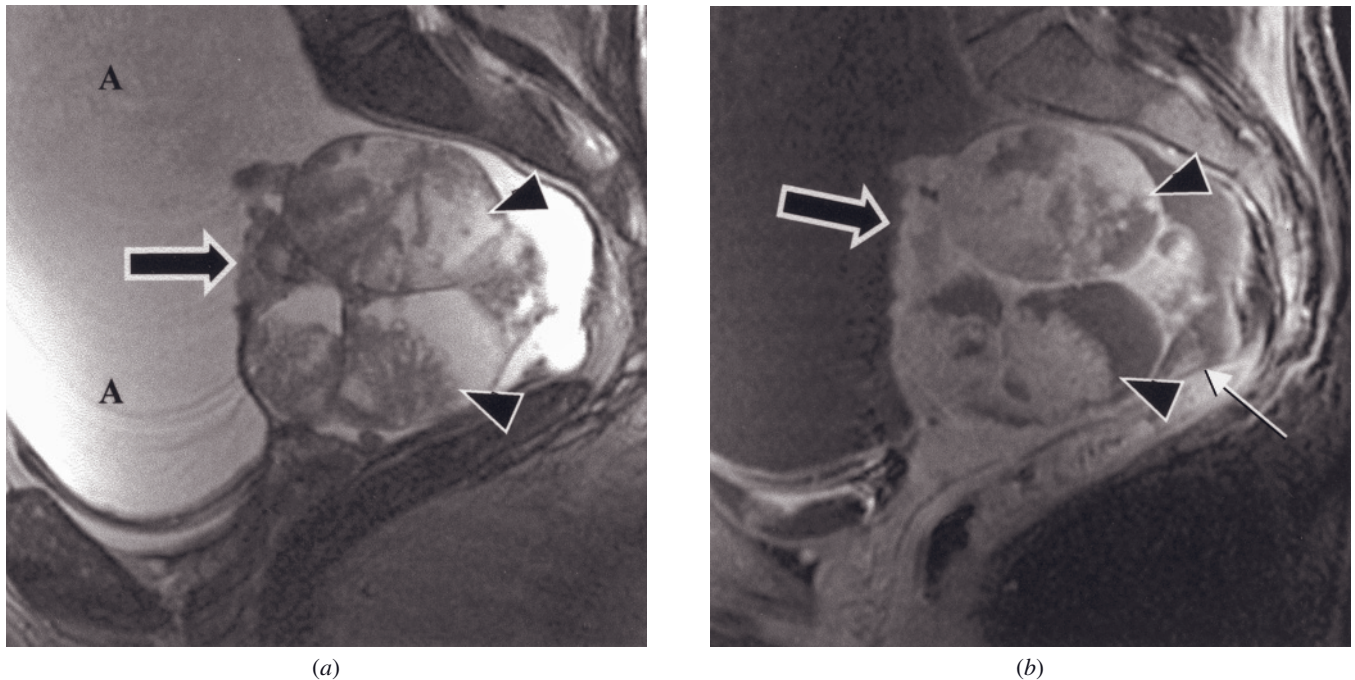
Serous cystadenocarcinoma. Sagittal T2-weighted ETSE image (*a*) and sagittal T1-weighted fat-suppressed gadolinium-enhanced image (*b*) images. T2-weighted image shows a right ovarian mass with irregular solid components (arrow, *a*) and florid intracystic papillary projections (arrowheads, *a*). Ascites (A) is present, with implants in the cul-de-sac. Gadolinium-enhanced T1-weighted fat-suppressed gadolinium-enhanced image (*b*) shows enhancement of the papillary projections (arrowheads, *b*) and solid components (arrow, *b*) and implants (thin arrow, *b*).
